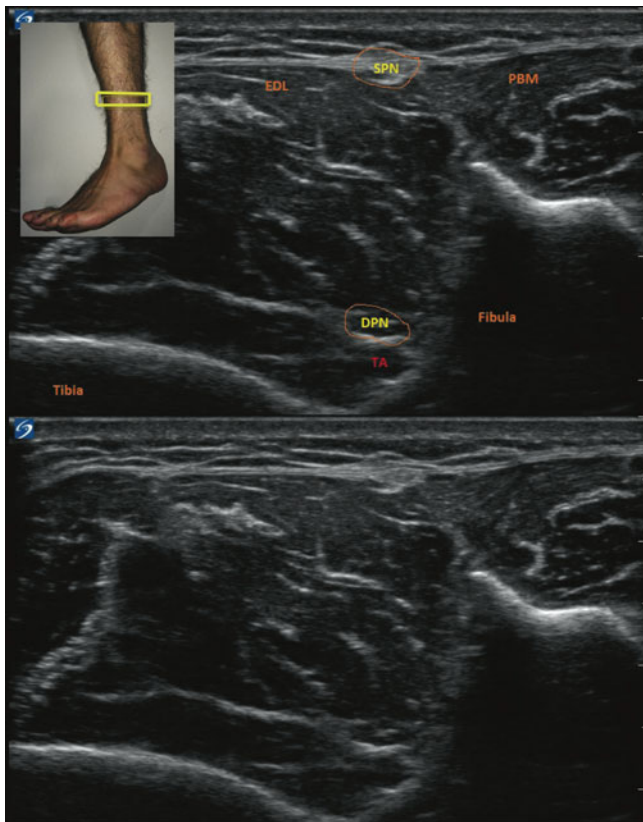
Ultrasound imaging of the common peroneal nerve, showing the split between the deep and superficial peroneal nerves at the shin. *TA* tibial artery, *DPN* deep peroneal nerve, *SPN* superficial peroneal nerve, *EDL* extensor digitorum longus muscle, *PBM* peroneal brevis muscle (Image courtesy of Agnes Stogicza, MD)
